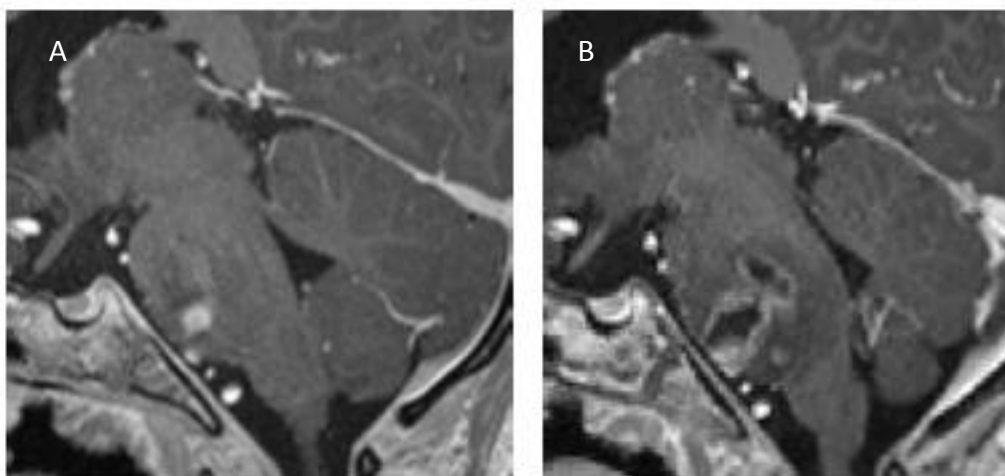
Vacuolation along a catheter trajectory following pontine infusion. Mid-sagittal plane of T1-weighted magnetic resonance image sequence with contrast before pontine infusion (A) and after pontine infusion (B) in a patient who received carboplatin monotherapy.
